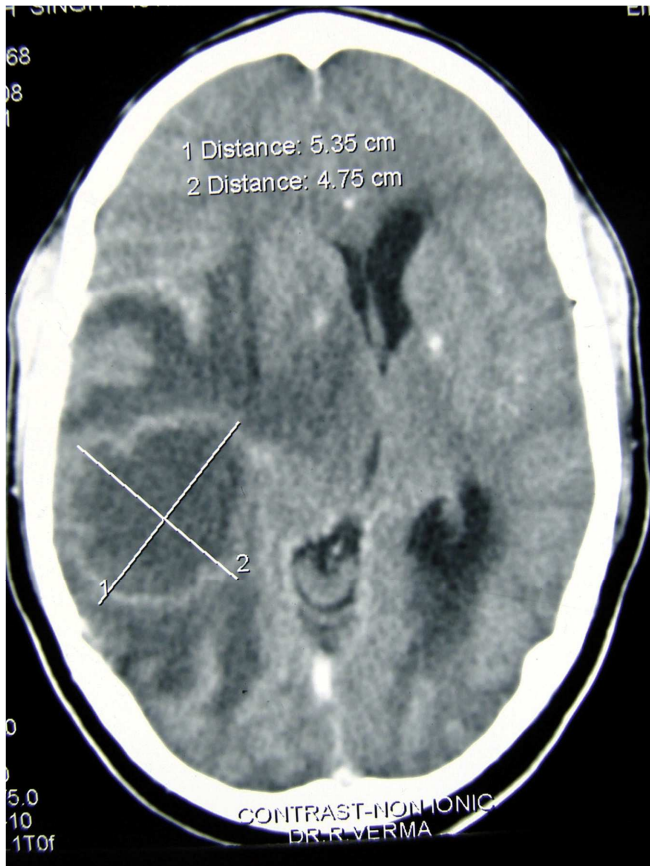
Axial CT scan of the brain showing solitary moderately enhancing ring lesion in the right temporo-parietal region with perilesional edema.
